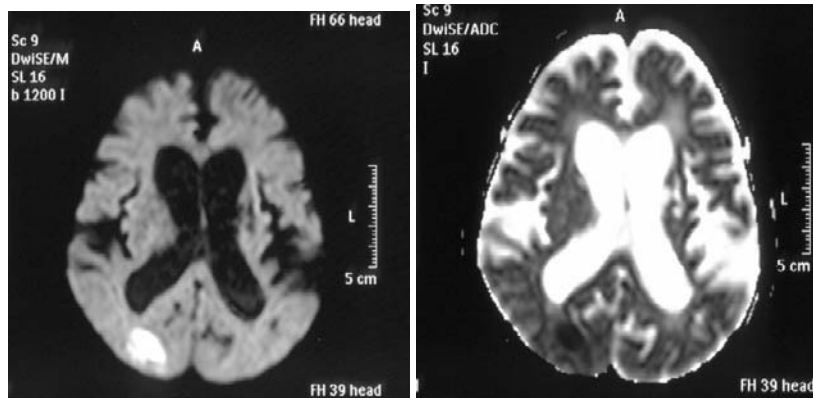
DWI (left) and ADC map (right)
